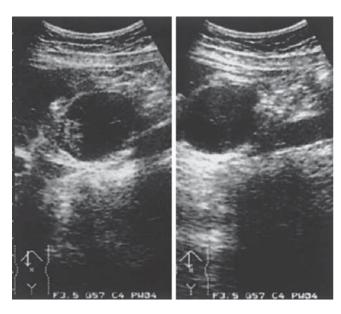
Ultrasonography showed a predominantly cystic mass in the head of the pancreas
